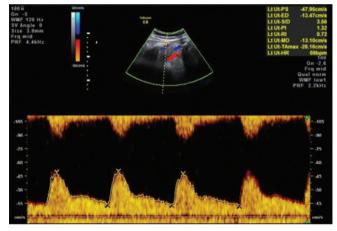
Doppler wave form of the left uterine artery showing raised resistive index and pulsatility index
